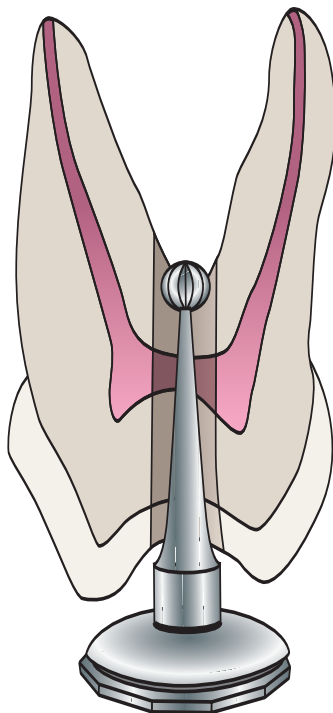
Operative errors—maxillary molars. One of the most common errors is perforation of the furcation while searching for a receded pulp with a surgical-length bur. Wider access helps prevent these accidents, as does measuring the depth on the radiograph. These perforations may be repaired with placement of mineral trioxide aggregate (MTA, Dentsply/Tulsa).
